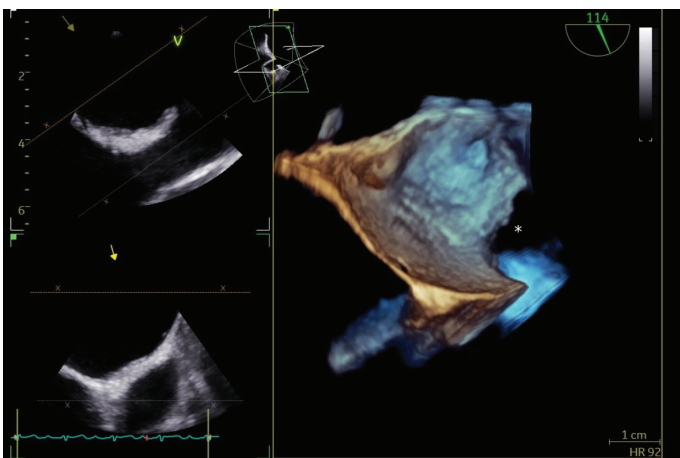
The 3D transesophageal echocardiography view shows the superior sinus venosus atrial defect (*).
